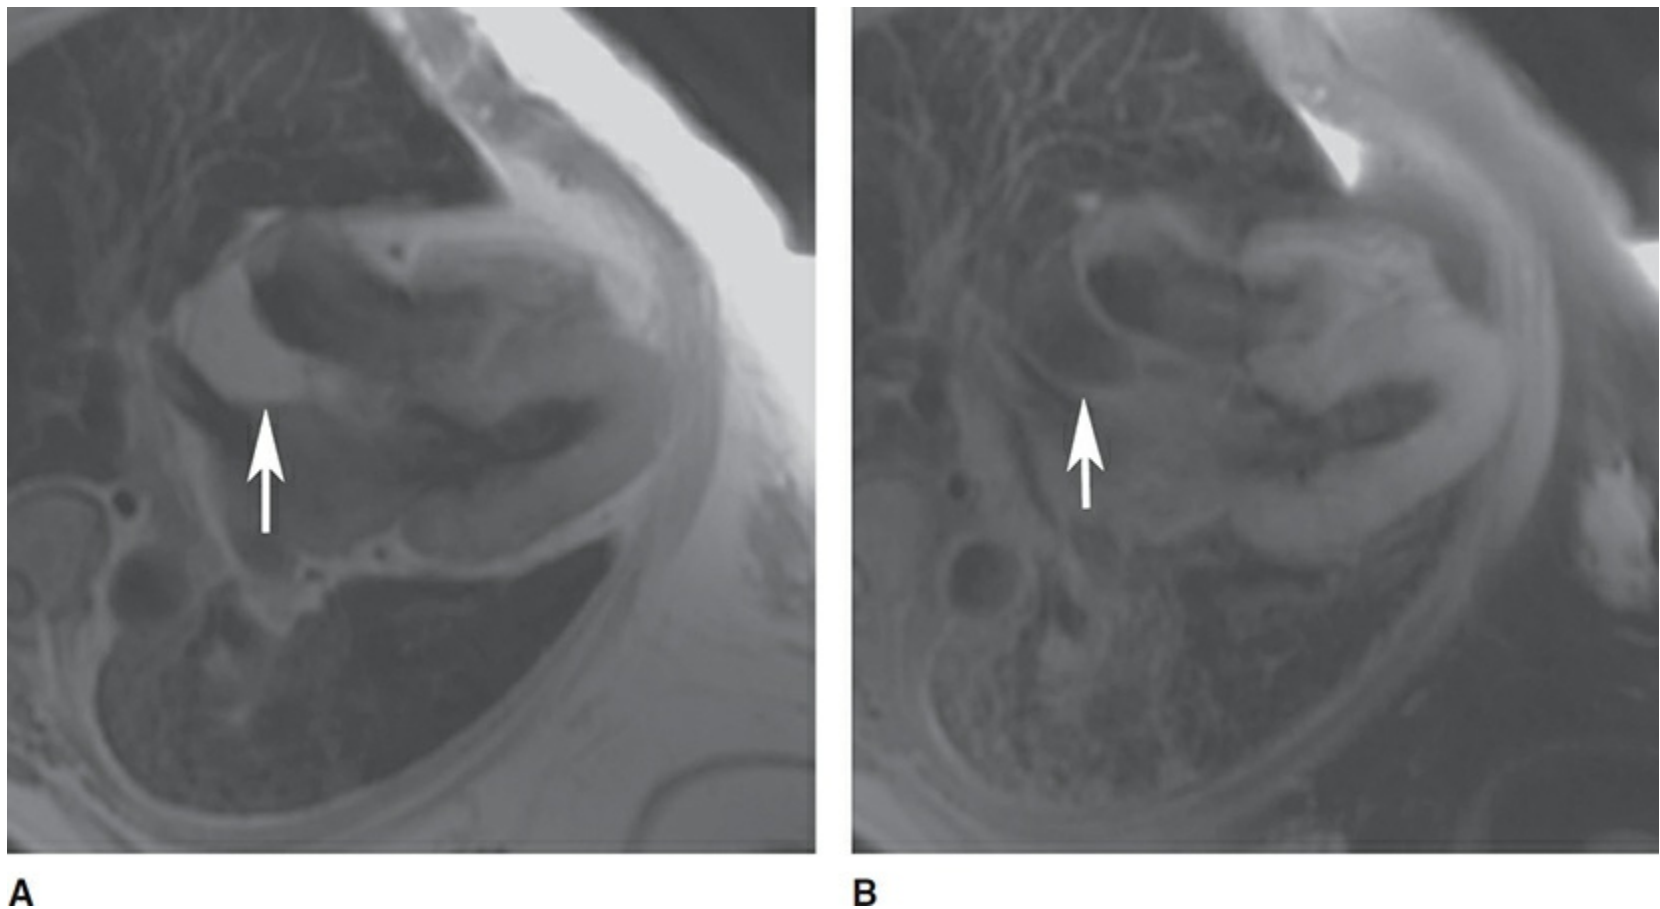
On standard T1-weighted spin echo images, the lesion is hyperintense (A; arrow). After the application of a fat suppression pulse, the signal from the lesion is nulled (B; arrow).
